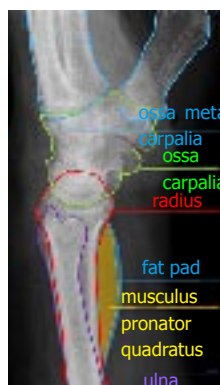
Anatomical sketch of conventional radiograph on lateral view of wrist.
